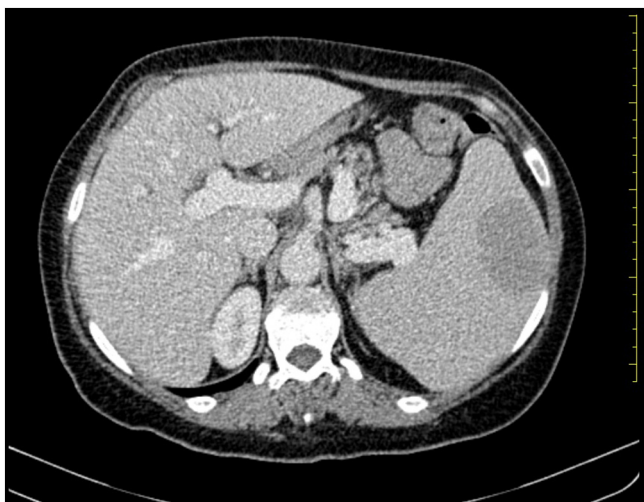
CT scan showing an intra-parenchymal lesion of 5 cm in a 26-cm interpole diameter spleen.
